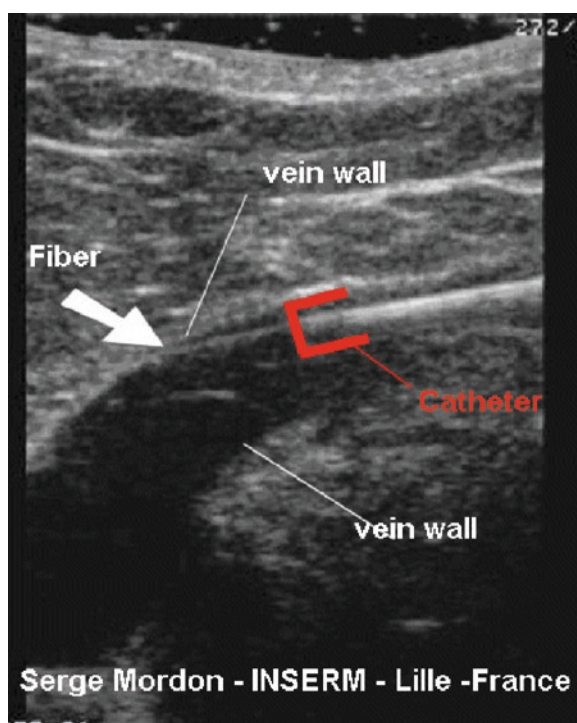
Ultrasound image showing the fiber in contact with the vein wall
